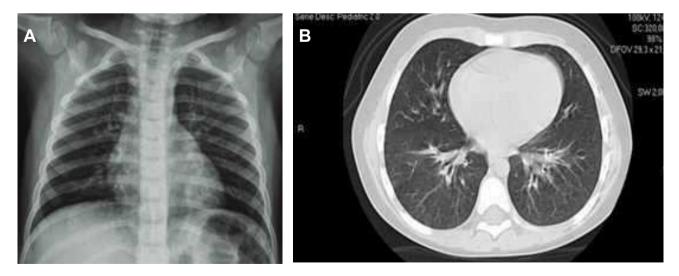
Chest X-ray (A) and CT (B) scan performed 3 months after exposure to glitter. Signs of bronchiectasis can be observed in both lung bases.
